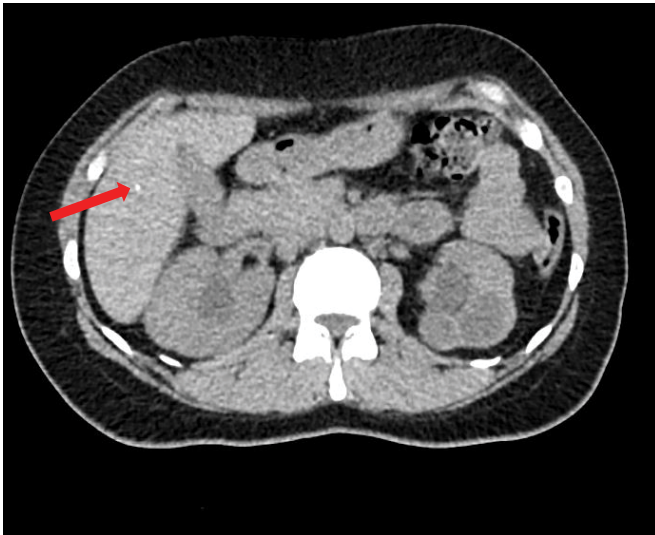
CT Abdomen Axial view showing tiny calcified granuloma in the right hepatic lobe.
